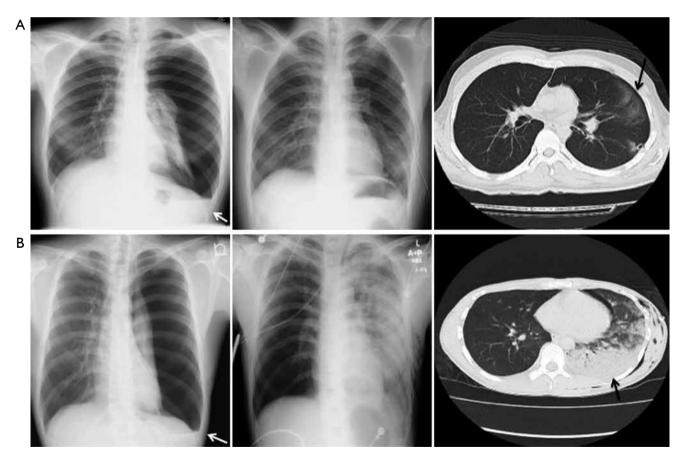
Representative chest radiographs and CT scan of a pneumothorax that was associated with the development of asymptomatic RPE (A) and symptomatic RPE (B). Both figures show X-rays of pleural effusion (white arrow) in addition to pneumothorax (left column). Both of the X-rays taken after tube thoracostomy reveals a hazy ground-glass infiltrate in the left lower-lobe (middle column). Right column indicates CT images of RPE (black allow); RPE, reexpansion pulmonary edema.
